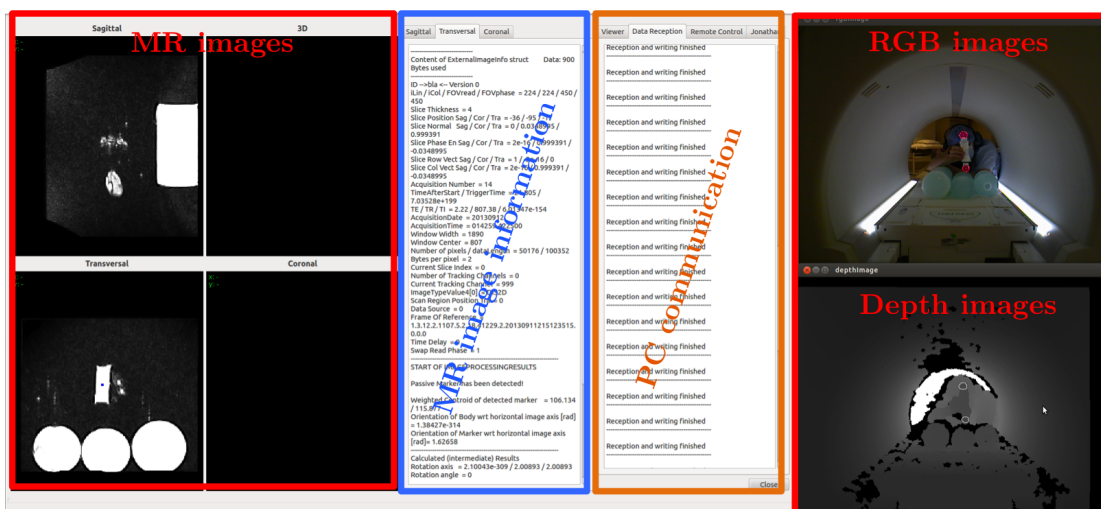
GUI screenshot of the developed program with the received MR and RGB-D images at the left and right, respectively. Image information and communication protocols between external and MRI console PC are depicted in the middle.
